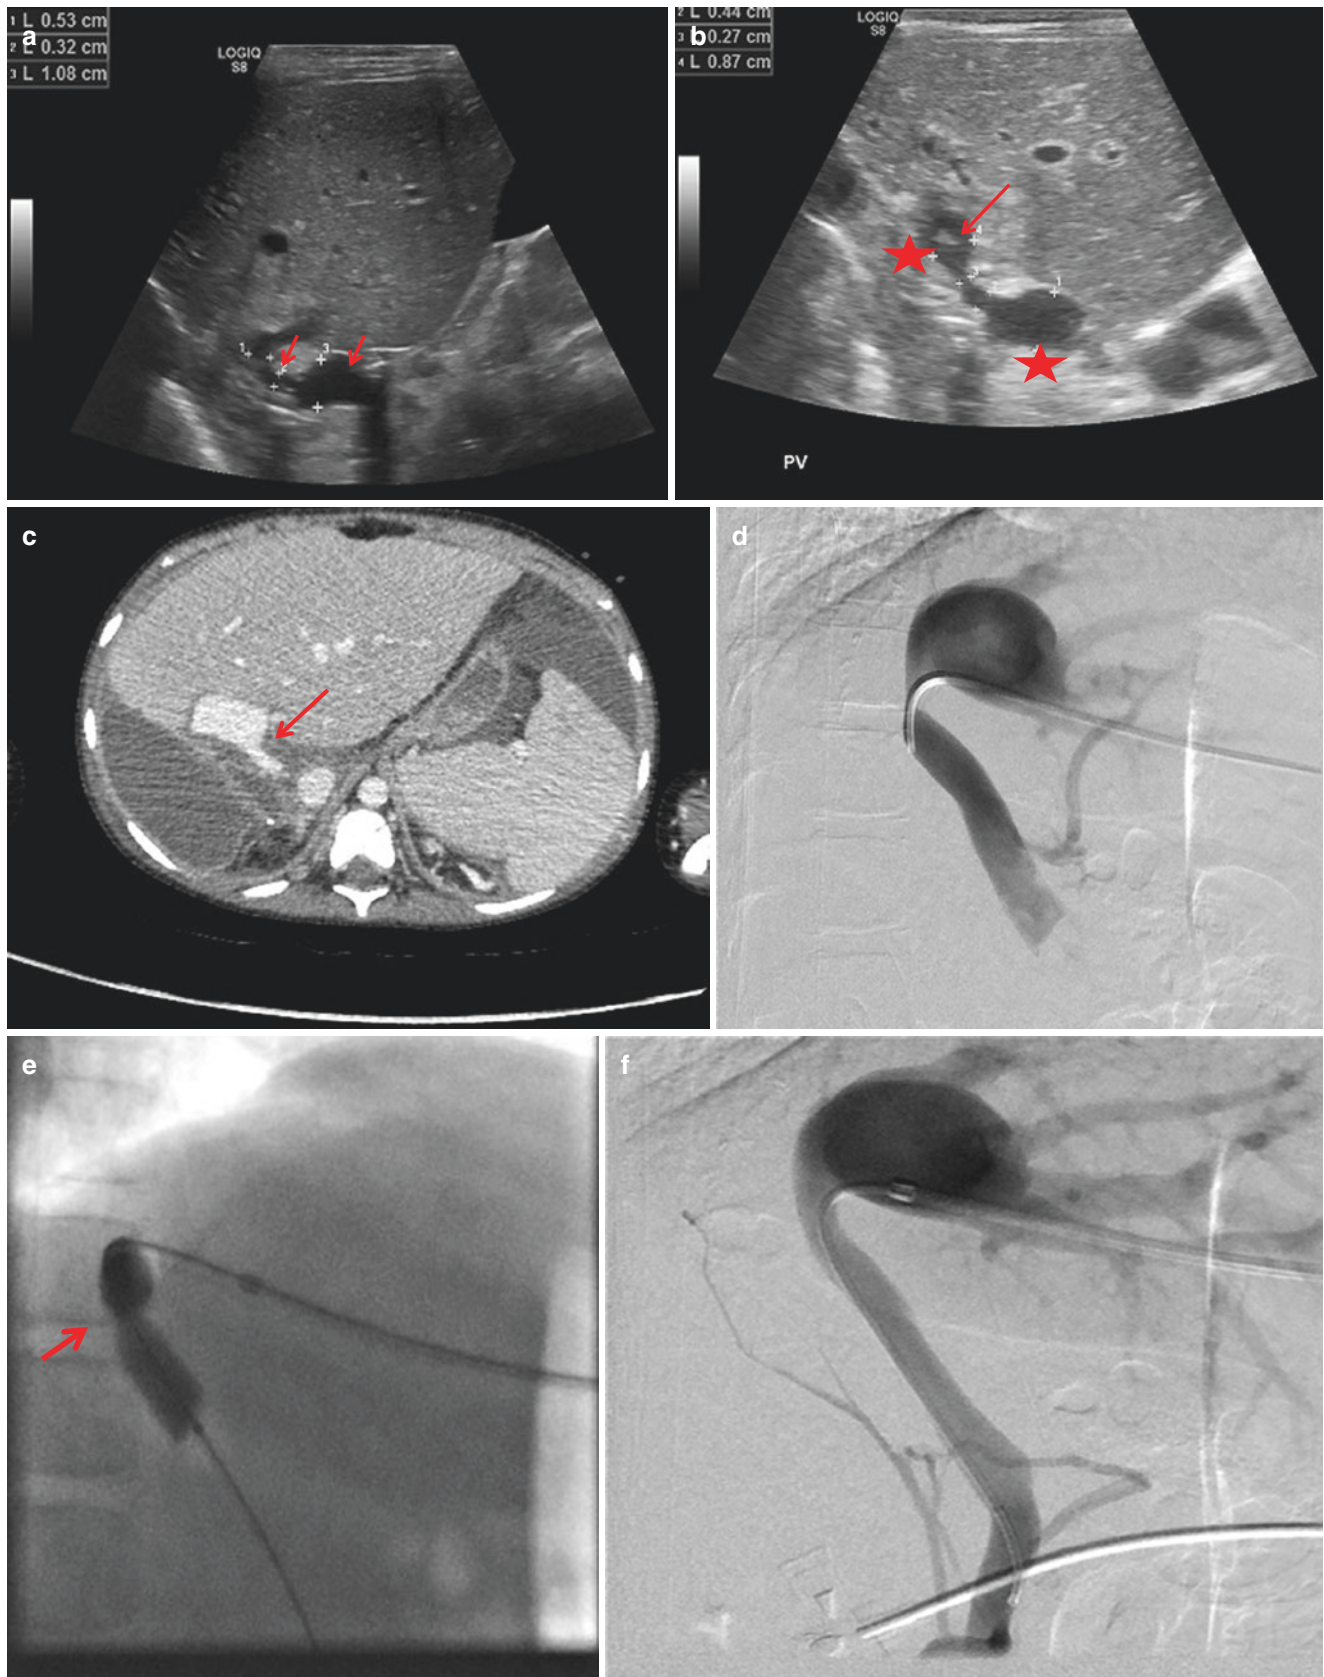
(a) Ultrasound scan showing narrowing with pre-stenotic dilatation (b) Ultrasound scan with pre and post stenotic dilatation (marked with star) and echogenic material in the post-stenotic dilatation (? Thrombus) marked with arrow. (c) Intravenous contrast axial CT scan of the abdomen reveals caliber change at the site of anastomosis
